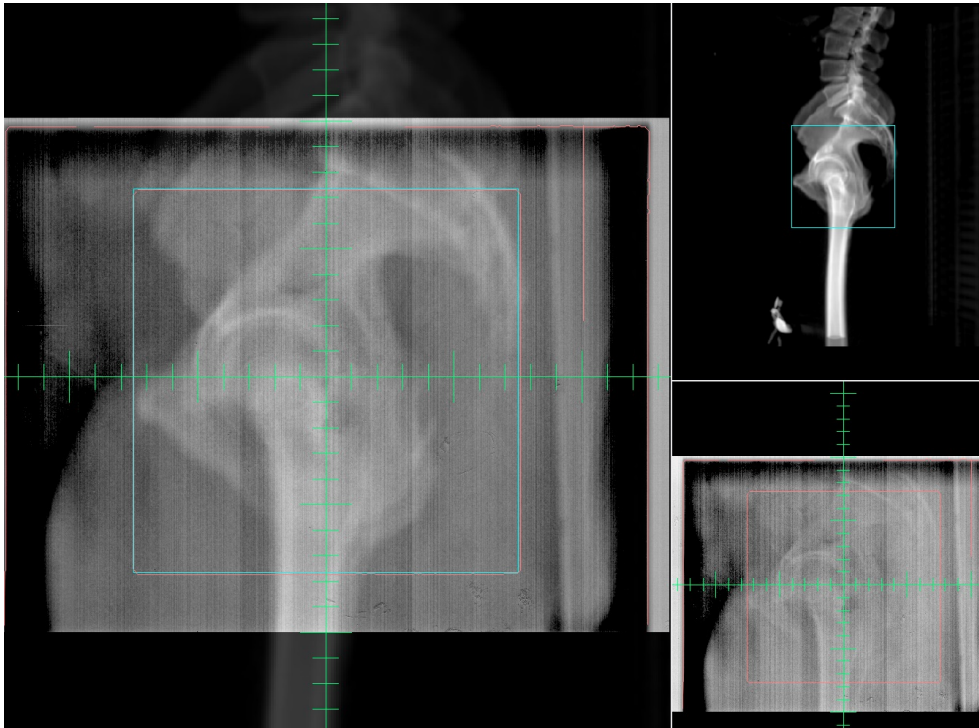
2D orthogonal kV projections (left) and DRR from planning CT for a prostate cancer patient (Images from Hospital Vitoria-BR).
